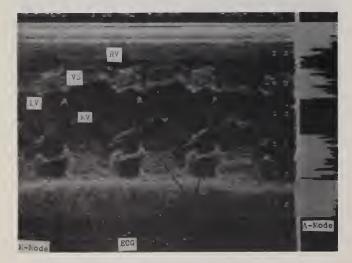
M-mode echocardiogram. The arrowed structures reflect the dilated CS. RV-right ventricle. VS-ventricular septum. LV-left ventricle.
